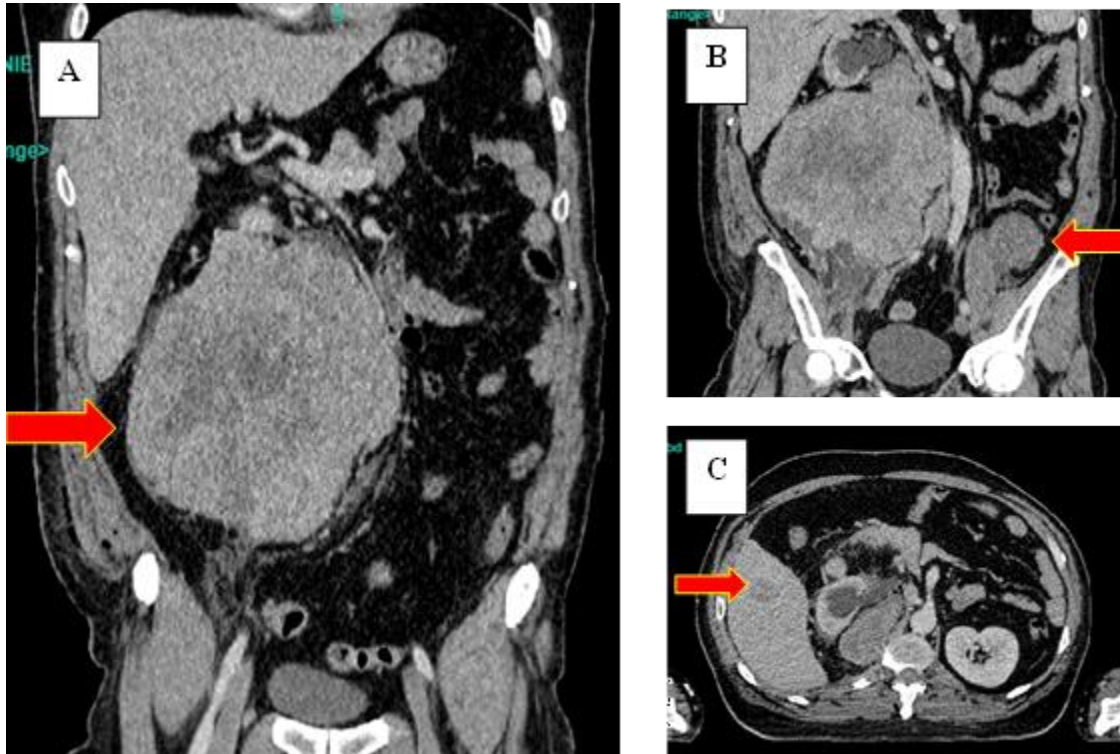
CT scan of the patient showing the patient's tumor. (A) Right iliopsoas muscle mass. (B) Left iliopsoas muscle mass. (C) Hypodense mass in the liver is suggestive of metastasis.
